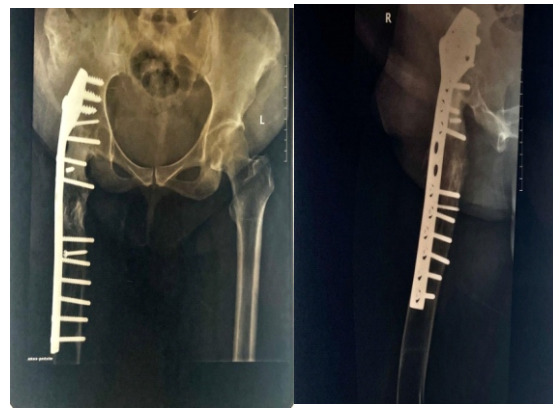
2013 follow-up radiograph.
